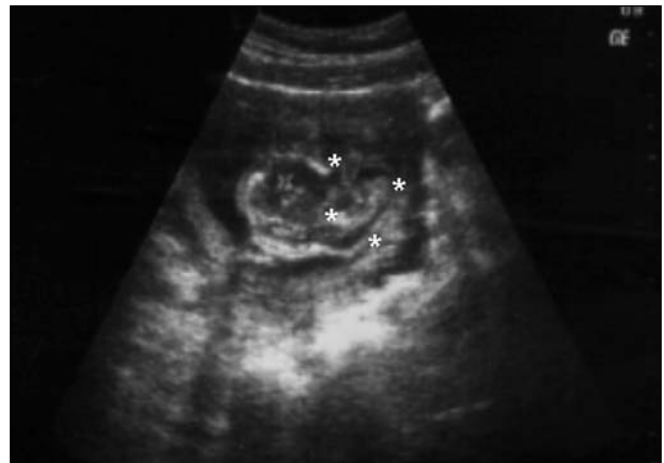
Frontal encephalocele was detected during the ultrasonographic examination.
